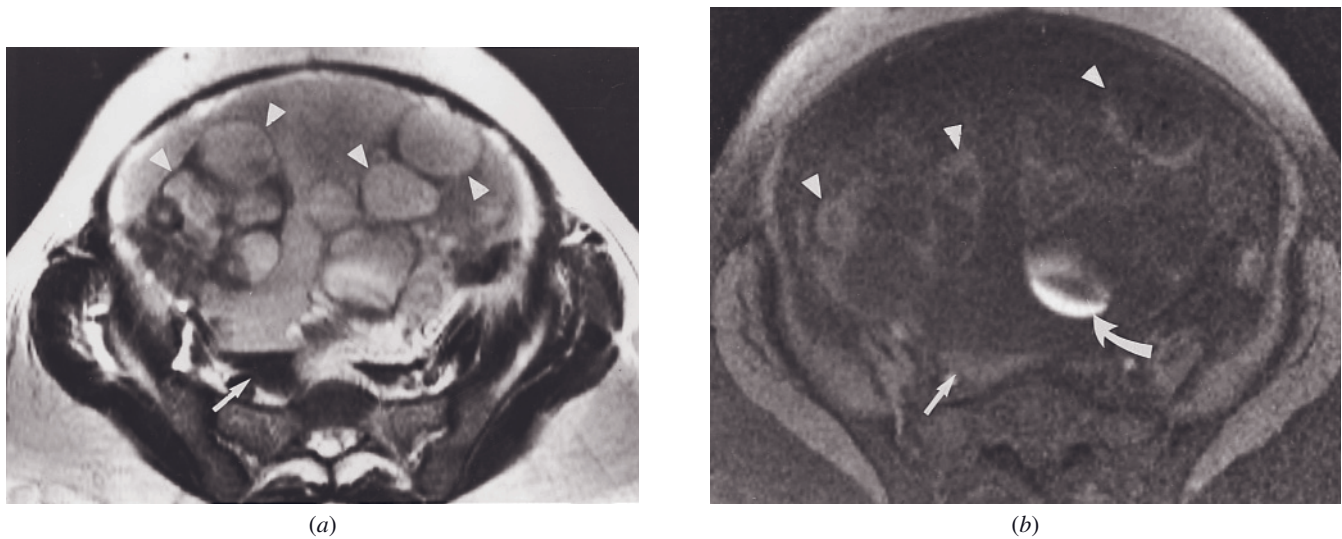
Theca-lutein cysts in ovarian hyperstimulation syndrome. Transverse T2-weighted ETSE (*a*) and T1-weighted gradient-echo fat-suppressed gradient echo (*b*) images in a patient on ovulation induction medicine who presented with acute pain and hypotension. Bilateral multilocular ovarian cysts (arrowheads, *a, b*) are identified in association with a gravid uterus (not shown) and marked free abdominopelvic fluid. Some of the cysts are complicated by hemorrhage, which is best seen on the fat-suppressed T1-weighted images (curved arrow, *b*). There is also evidence of hemoperitoneum. Note that the dependent fluid is intermediate in signal intensity on the T1-weighted images and is decreased in signal intensity on T2-weighted images, which is consistent with intracellular methemoglobin (arrows, *a, b*). The hyperstimulation syndrome is a well-recognized, life-threatening complication of ovulation induction therapy for infertility.
